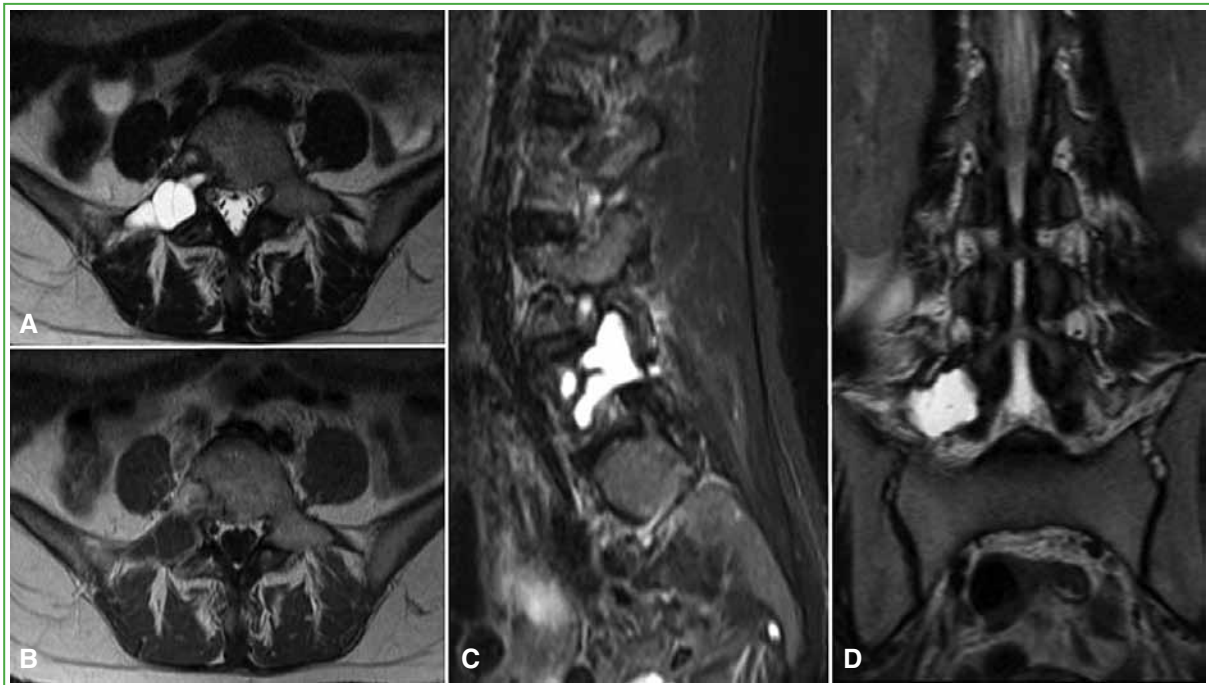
Magnetic resonance imaging. A. T2-weighted sequence, axial section. B. T1-weighted sequence, axial section. C. STIR, sagittal section. D. T2-weighted sequence, coronal section. Lesion of fluid signal intensity (hyperintense on T2-weighted and STIR sequences and hypointense on T1-weighted sequences) with internal septa, expansile with thinning of the cortex and centered on the right pedicle of L5 and extension into the vertebral body, facet and the right transverse process.
